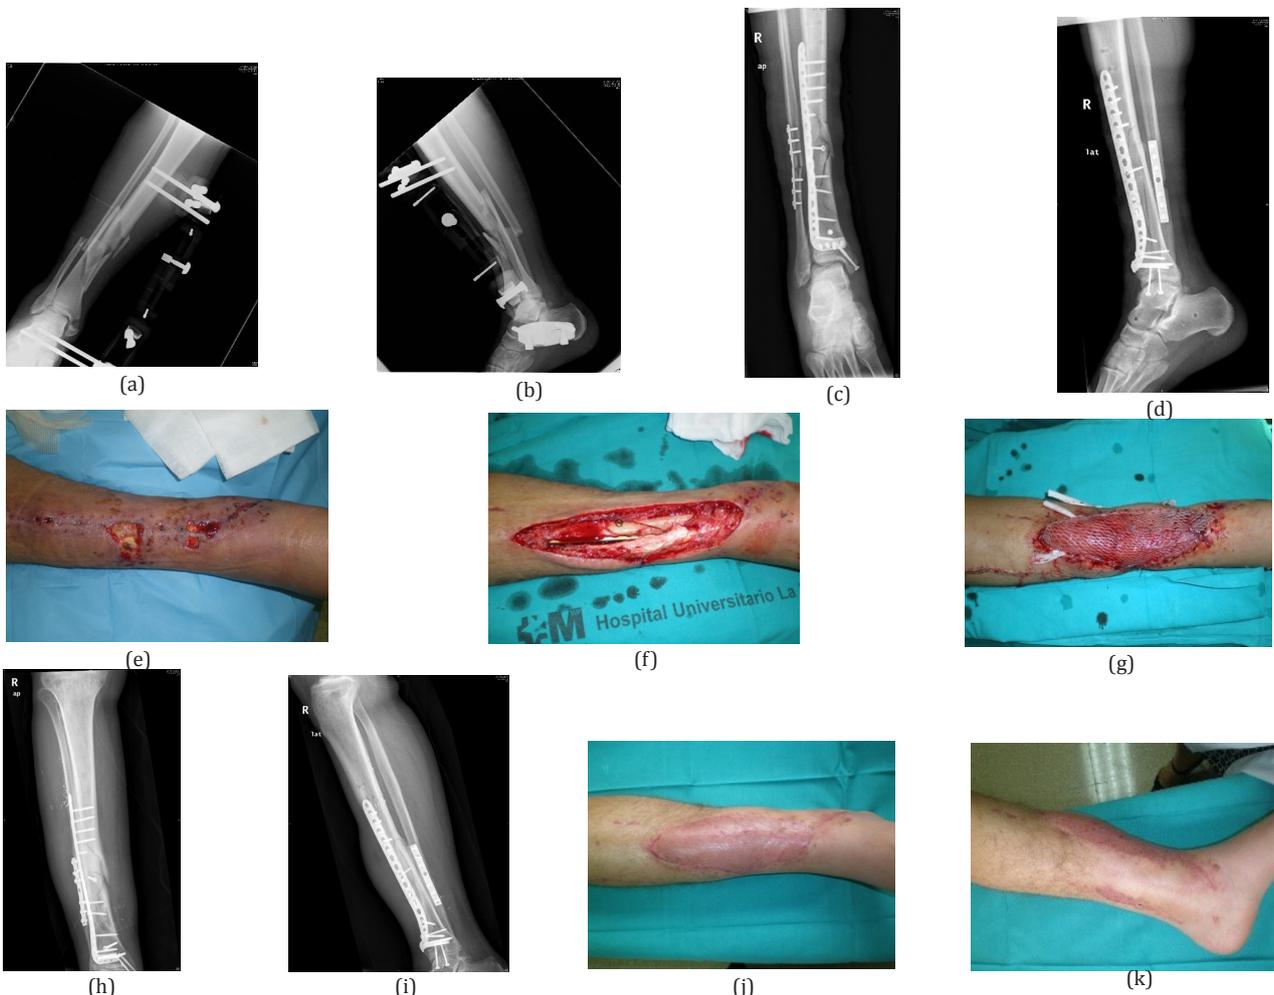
Fracture of the distal tibia with joint involvement, initially treated with an external fixation device: (A) Anteroposterior (AP) radiograph of the fracture; (B) Lateral image of the fracture. Radiographs of fracture (C) and (D) after definitive treatment by means of open reduction and internal fixation (ORIF) with a 3.5mm fibular plate and an locking compression plate (LCP) 3.5mm anterolateral distal tibia plate, together with two 3.5mm screws in the medial malleolus. (E) Image showing the evolution of the soft tissues one week later, evidencing cutaneous necrosis and suture dehiscence. Intraoperative images showing extensive debridement performed in the area of cutaneous necrosis and devitalized tissues (F) and coverage carried out using a latissimus dorsal flap and meshed epidermal graft (G). Radiographic images showing the evolution at 6 months: (H) AP radiograph showing the consolidated fracture in good position; (I) Image in lateral projection showing the aforementioned bone healing. Images (J) (K) in which the clinical appearance of the covering flap can be seen.
